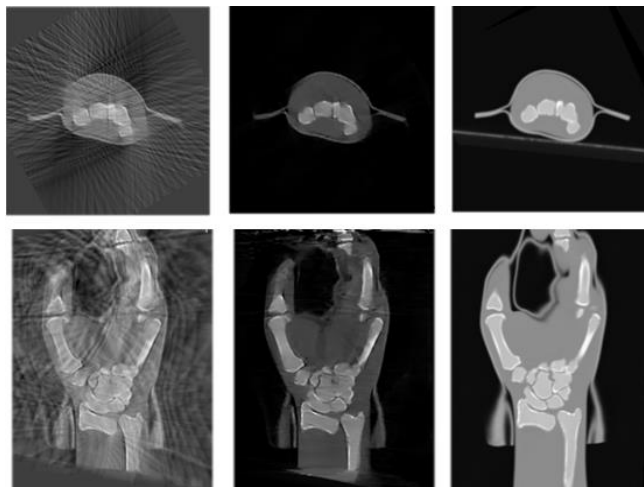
Axial and coronal views of the reconstruction of the limited data obtained on the C-arm with FDK (left) and SCCS (center). Axial and coronal views of the CT volume acquired on the helical scanner (right).
